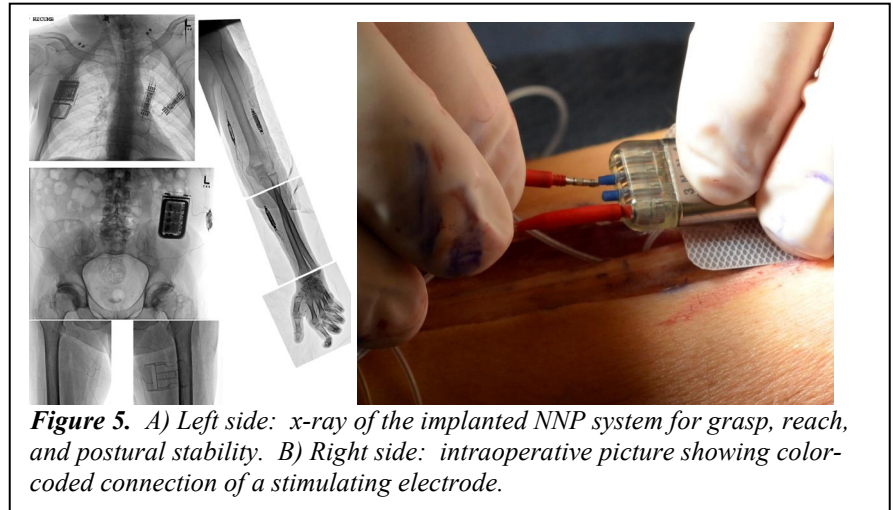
A) Left side: x-ray of the implanted NNP system for grasp, reach, and postural stability. B) Right side: intraoperative picture showing color-coded connection of a stimulating electrode.
